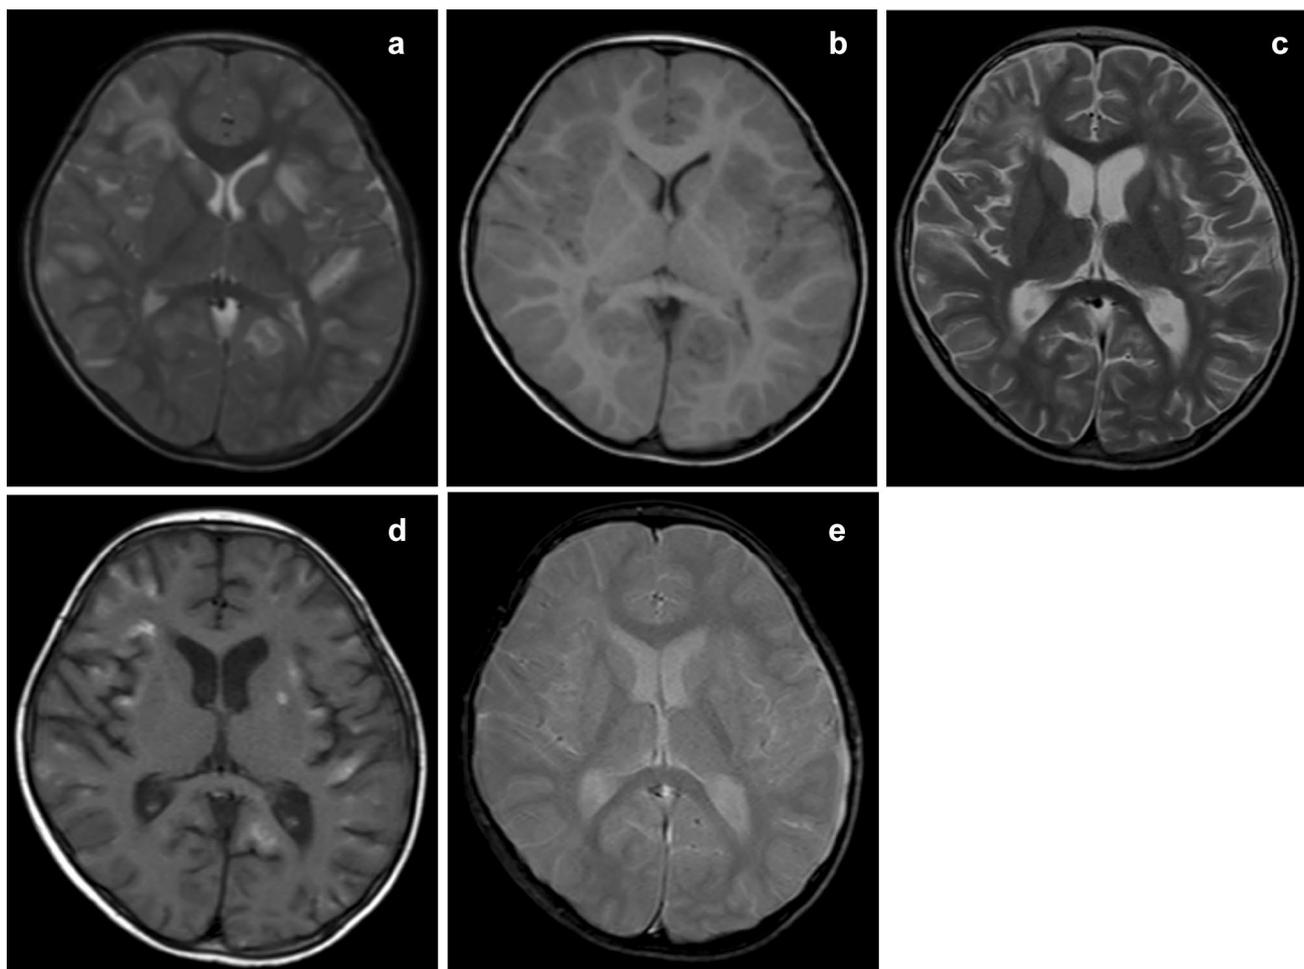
Two-year-old boy with ADEM (Case 1). a T2-weighted image (T2WI) on admission (7 days after onset) demonstrated multifocal, hyperintense, bilateral, asymmetric lesions in the white matter. b T1-weighted image (T1WI) showed slightly low intensity. c Lesions
